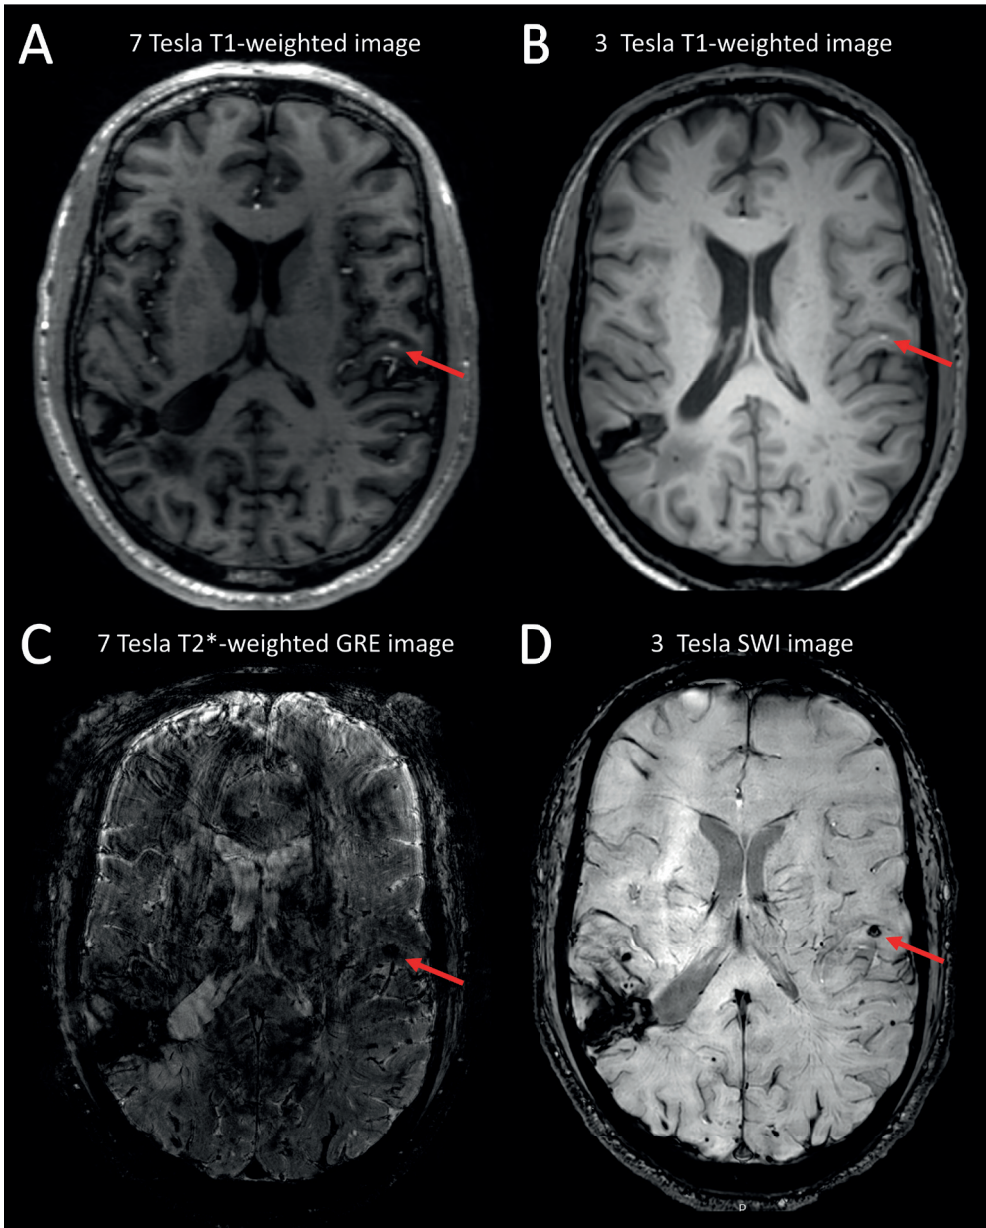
7 Tesla and 3 Tesla MRI imaging of an acute CMB (confirmed on follow-up imaging) in a D-CAA mutation-carrier with ICH. A chronic ICH is visible in the right hemisphere. A) 7T T1-weighted image showing an acute CMB (red arrow), B) 3 Tesla T1-weighted image, showing the corresponding acute CMB C) 7T T2*-weighted gradient echo image, showing a hypointensity; note that image quality was poor, but blooming effect could still be appreciated D) 3T SWI image showing a hypointensity with blooming effect.
